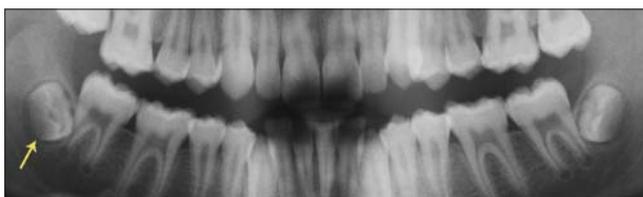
Patient radiograph: Lower right third molar at Nolla's 6th developmental stage (arrow)
